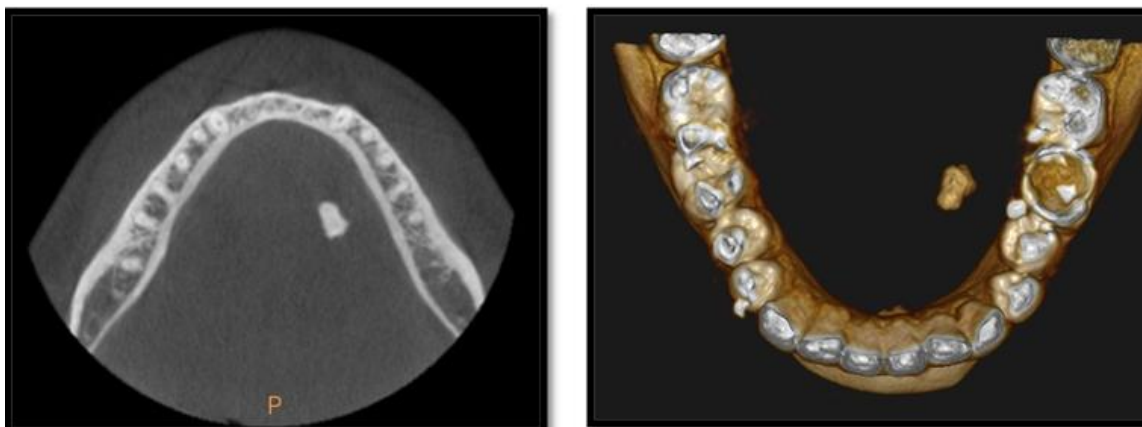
CBCT, Axial section showing well-defined radiopacity in the left submandibular region.
